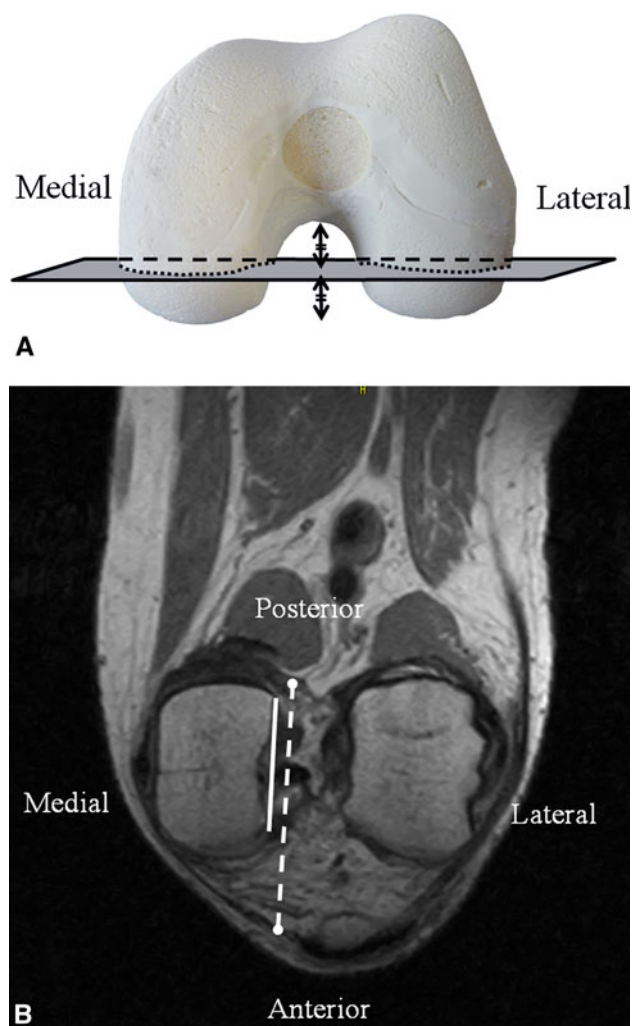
B (A) The photograph shows how we selected the femoral condyle plane (gray plane) as the plane dividing the posterior femoral condylar surface and the center of the intercondylar notch in half. (B) The MR image shows how the medial border of the patellar tendon and the middle of the PCL (two white circles, respectively) were projected into the femoral condyle plane. A line was drawn on the medial wall of the intercondylar notch (white solid line) and the AP axis of the tibia (broken line) and the angle between these lines was measured. The contour of the medial wall of the notch on the femoral condyle plane was classified as flat, concave, or convex in relation to the position of the line drawn from the anterior edge of the wall to the posterior edge of the wall.
